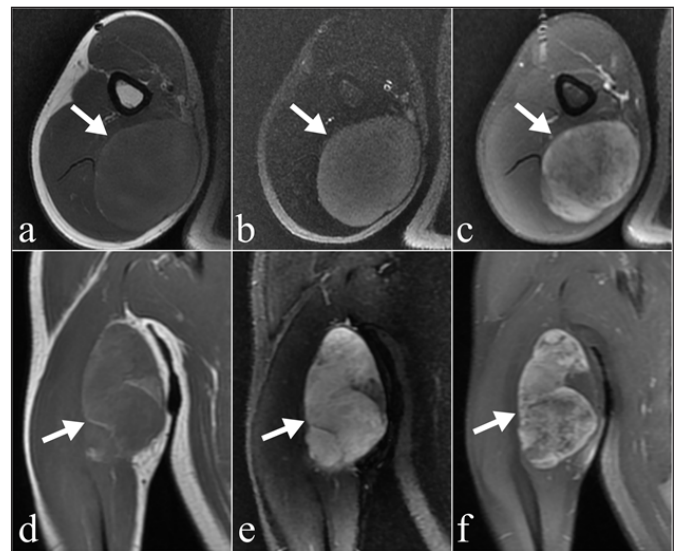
Images show MRI features in a 34-year-old male with FNCLCC grade 2 myxoid liposarcoma. MRI protocol included, a, axial T1-weighted imaging, b, axial T2-weighted imaging with fat-suppression, c, axial post-contrast T1-weighted imaging, d, e and f, coronal plans of the same sequences, respectively. There is a high T1 signal of hemorrhage in the tumor and mild peritumoral edema is present in the inferior.
